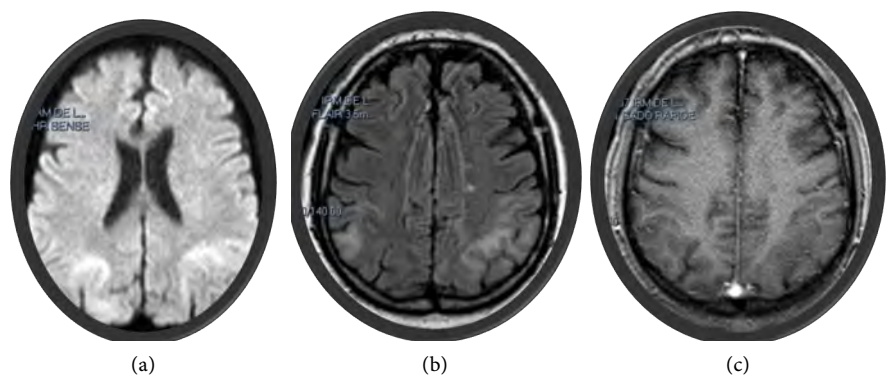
Appearance of the first neurological symptoms. Brain MRI. Lesions are indicated by the blue arrows. (a) Diffusion sequence: bilateral parieto-occipital hyperintensity, involvement of U-shaped fibers; (b) Axial FLAIR: biparietal hypersignal with U-shaped fibers; (c) T1 axial + gadolinium: hypo-parieto-occipital signal, absence of enhancement of the lesion.
